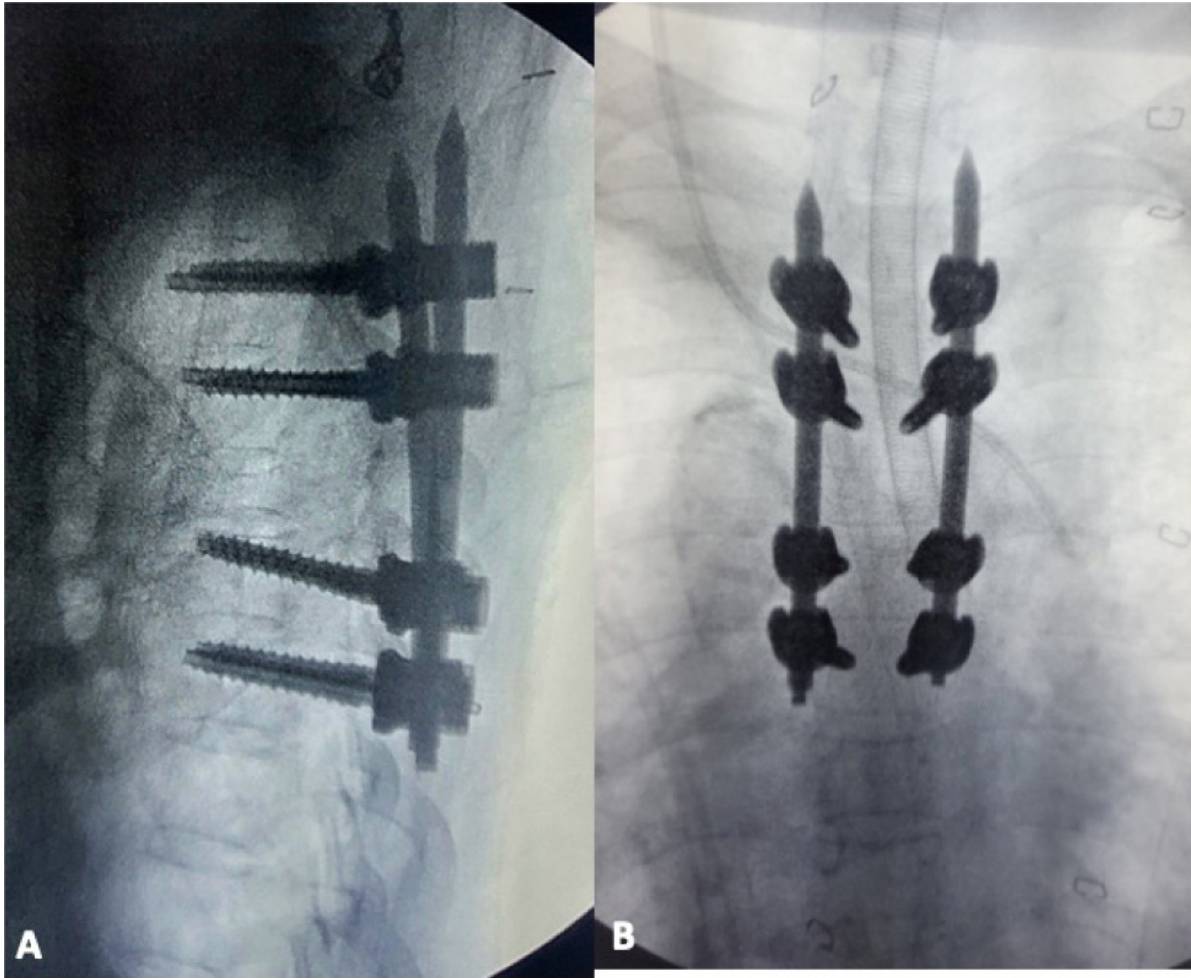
(A) Lateral and (B) AP X-ray showing T3-T7 PPSI done in a patient with T5 vertebral collapse secondary to tuberculosis.
